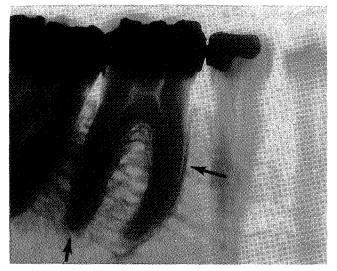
(a). This radiograph represents a view of the roots of molar and premolar teeth. The attachment of tooth to bone (the periodontal ligament) is indicated by the arrows.
